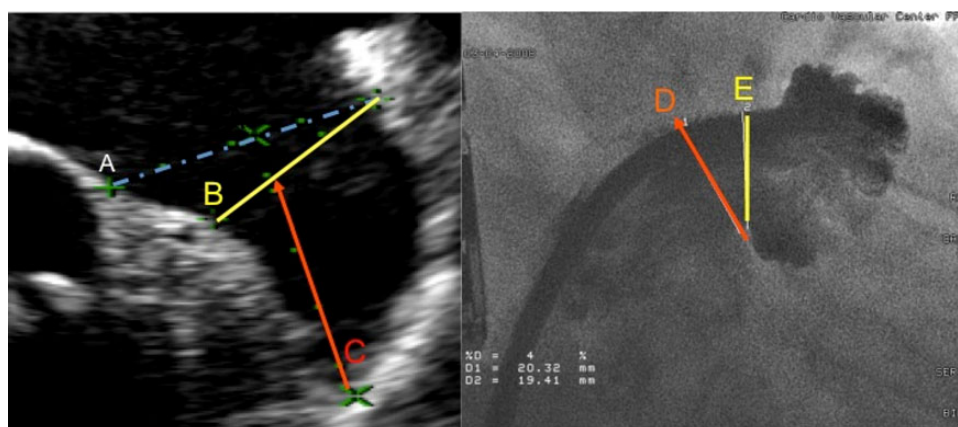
On the left-hand-side echocardiographic view, we see the ostium (A), landing zone (B), and length (C). The landing zone extends from the left circumflex artery to the other side of the LAA with 1 cm below the start of the pulmonary ridge. On the right-hand-side angiographic view, we see the ostium (D) and landing zone (E).
